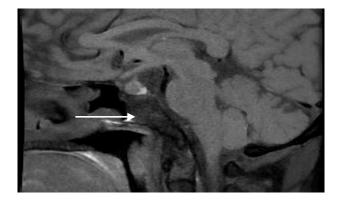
Sagittal section of T1 weighted image of MRI brain showing bright spot representing posterior pituitary.
